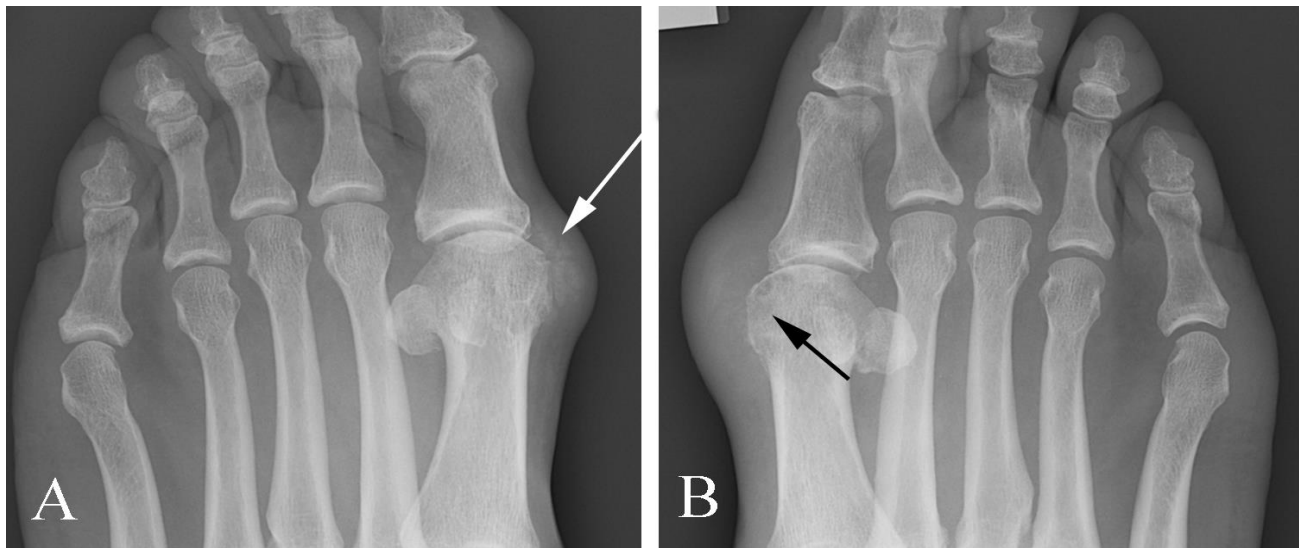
Gouty tophus in a 64 year old man with bilateral palpable lumps along the great toe metatarsal-phalangeal joints. A. Oblique plain film of the right foot shows a calcified soft tissue mass adjacent to the great toe metatarsal head (arrow). B. Oblique plain film of the left foot shows a tophus and also an underlying erosion of the great toe metatarsal head (arrow).
